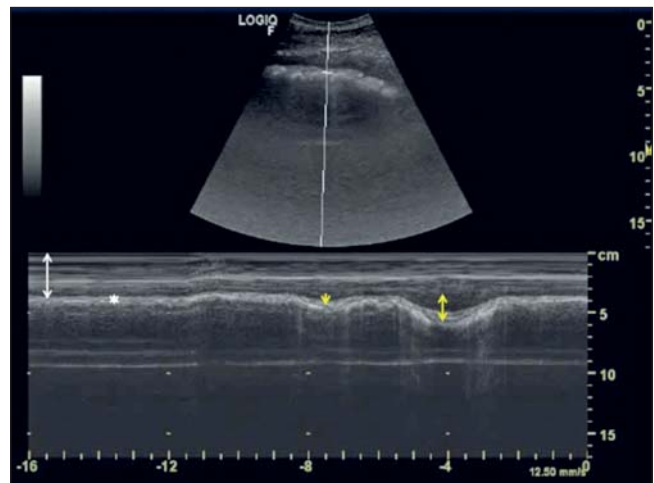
Ultrasonogram in B+M mode showing the parameters recorded in DH buffaloes; depth of the reticulum (white line), wall thickness of the reticulum (white star), amplitude of 1st phase of the reticular motility (yellow ray) and amplitude of 2nd phase of the reticular motility (yellow line).
